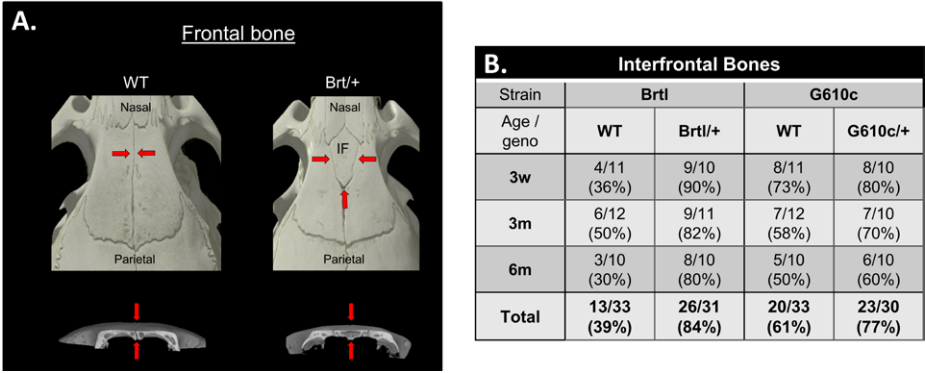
Interfrontal bone (IFB). (A) μ CT images of 3D reconstructed WT and Brtl/+ skull showing the presence of IFB in between the frontal bone. (B) Summary table of the IFB in Brtl and G610c at each age. Geno, genotype.
